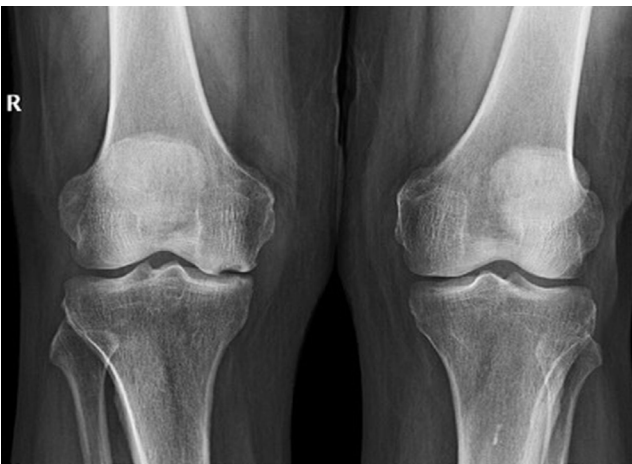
A standing anteroposterior radiograph showing a radiolucent lesion of the medial femoral condyle with a significant bony depression (crescent sign).
